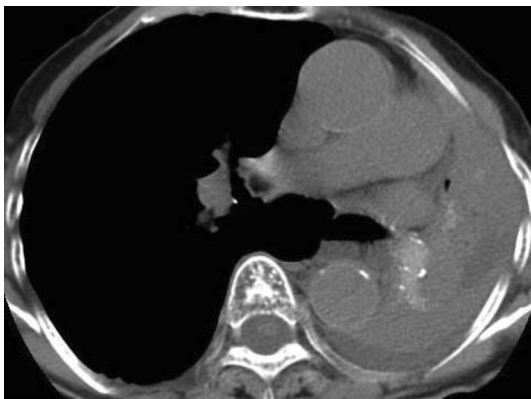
Chest computed tomography obtained upon admission shows complete collapse of the left lung with hyperattenuated mucoid impaction.
